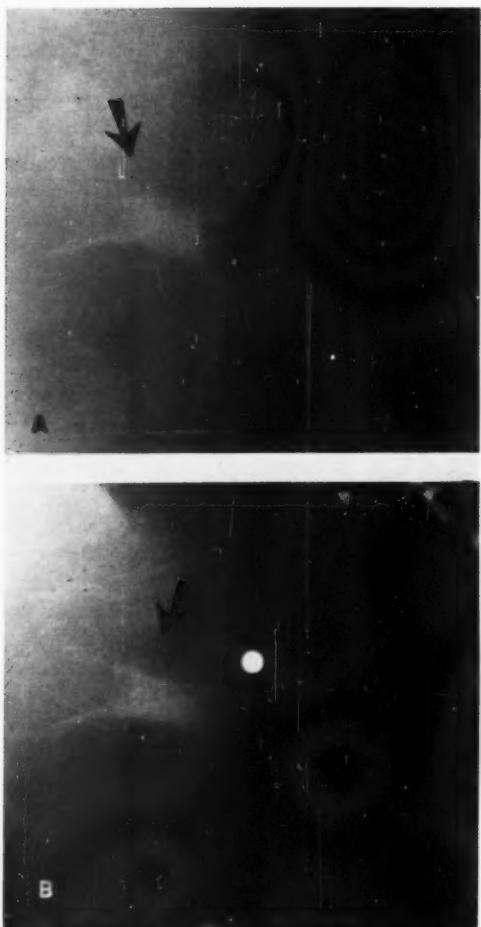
Slow growth of a duct carcinoma in an asymptomatic survey patient aged 68 years. The irregular spiculated mass (A) was not appreciated by the radiologist. The patient returned for examination six months later and, though a mass was still not palpable, an x-ray diagnosis of "suspicious malignancy" was made. At the end of eighteen months and four subsequent examinations (B), though still no mass was palpable, a quadrant dissection revealed an intraductal carcinoma 1.5 cm.  $\times$  0.8 cm.
